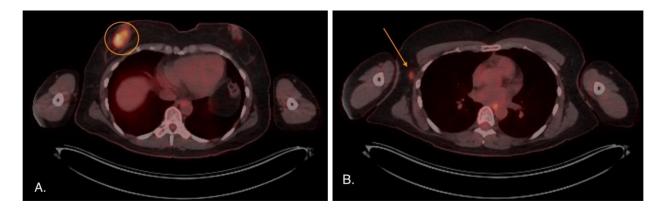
PET-CT demonstrates a hypermetabolic right breast lesion (circle) with a maximum SUV of 4.7 (A) and a small mildly hypermetabolic right axillary lymph node (arrow) with a maximum SUV of 2.2 (B).
